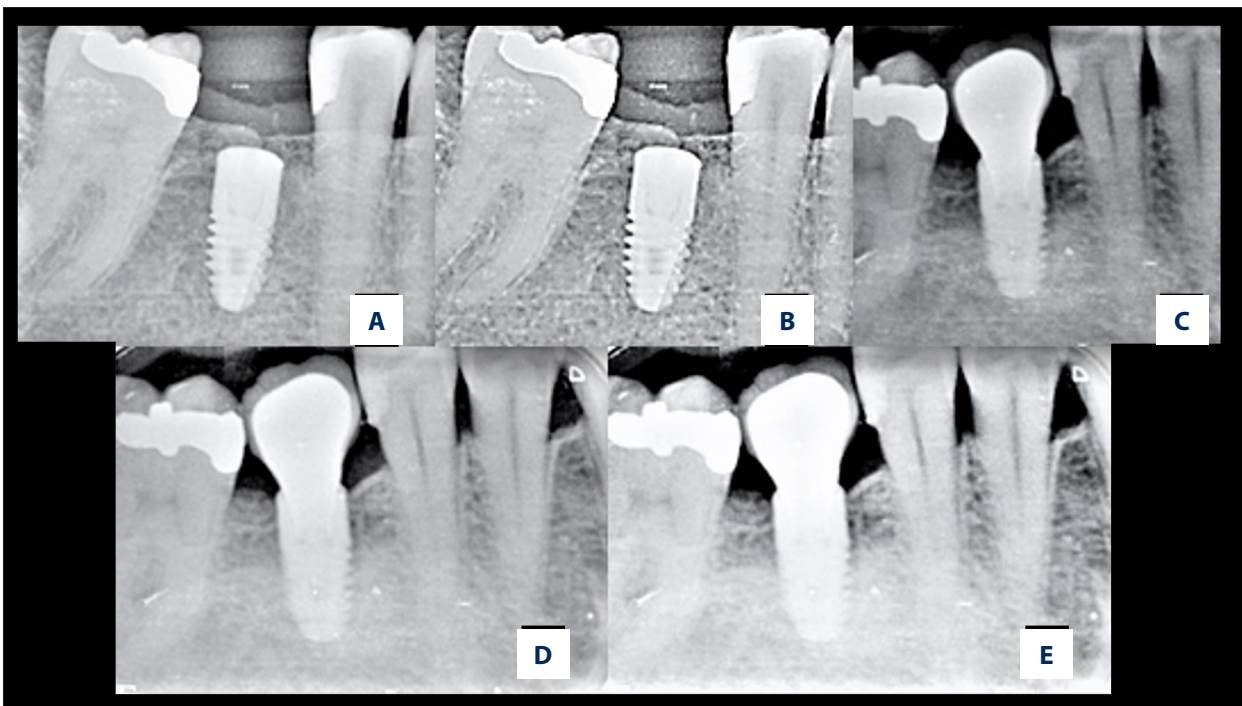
Radiographic interpretation of subcrestal implant placement (A) At the time of placement (B) At 3 months (C) At 6 months (D) At 9 months (E), At 12 months. *Figure created using MS PowerPoint, version 20H2 (OS build 19042,1466), Windows 11 Pro, Microsoft corporation).*
